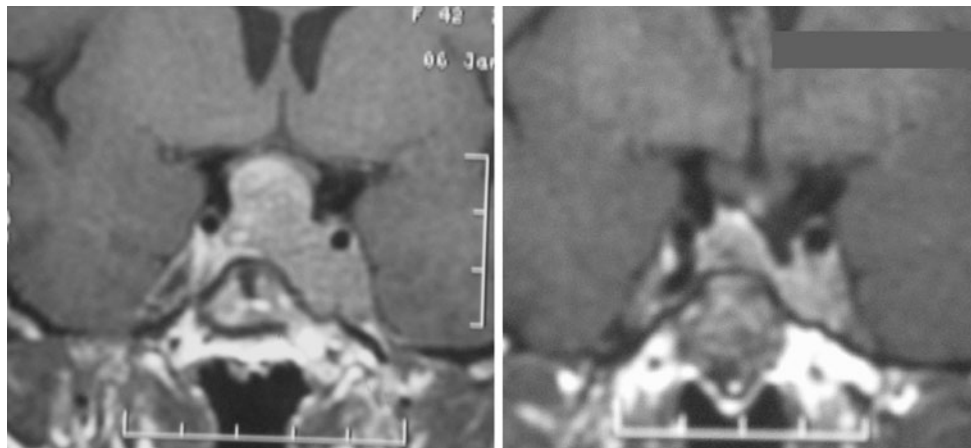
Pituitary MRI before and after a 6-month treatment with cabergoline 1.5 mg/week
